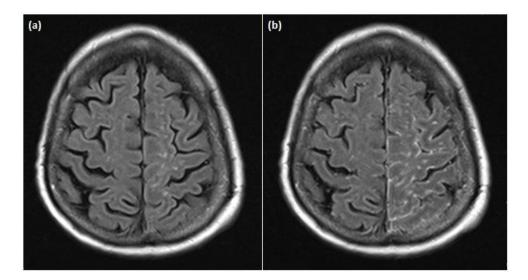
Flair axial views (a) pre-contrast and (b) post-contrast: Magnetic resonance imaging (MRI) of the brain demonstrating meningeal enhancement and raised T2 subcortical white matter signal in the left fronto-parietal region towards the vertex and extending over the temporal lobes bilaterally
